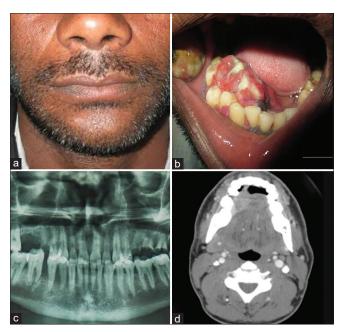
(a) Extraoral photograph, (b) intraoral growth in the lower right quadrant, (c) orthopantamogram (OPG) showing radiolucency in the lower right quadrant. (d) Computed tomography (CT) revealed an ill-defined intensely enhancing mass lesion seen in the right buccal mucosa near the alveolar ridge and adjacent to the tongue
